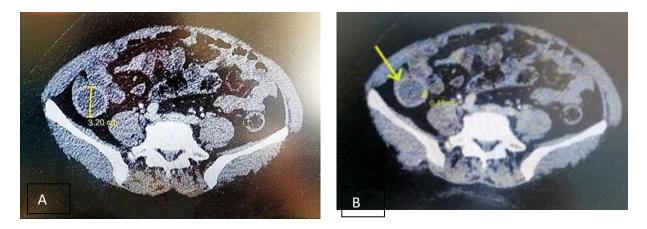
A. Abdominal computed tomography (CT) image showing a cystic-like structure measuring approximately 3.2 cm in diameter. B. The thick (0.48 cm) enhanced wall of the cystic-like structure.
